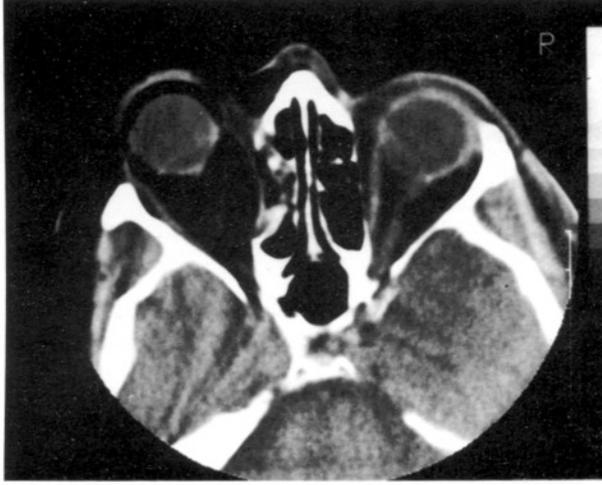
Orbital CT scan showing the defect of lamina papyracea on the left orbital wall and massive intraorbital air.
